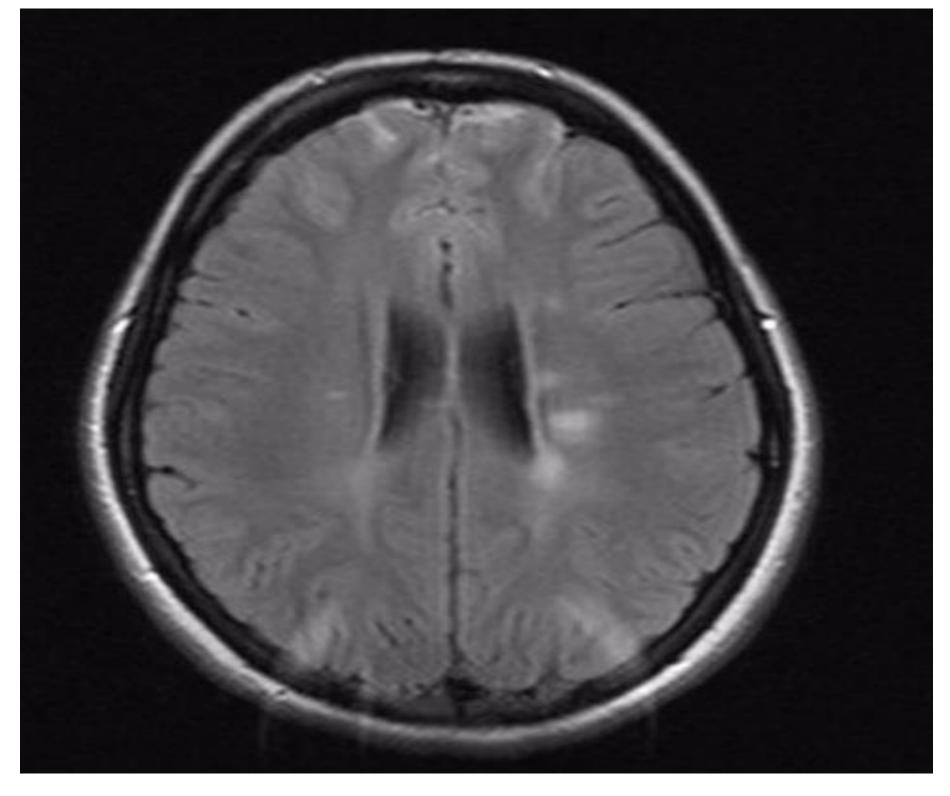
Brain MRI June, 2015
